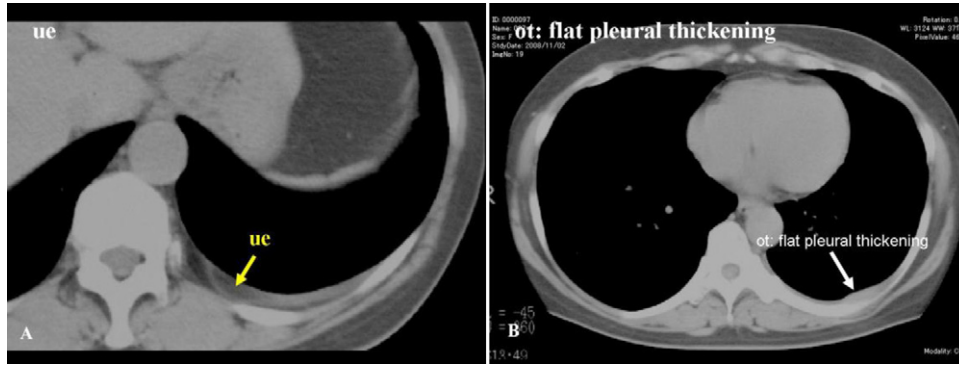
A 52-year-old women with diffuse epithelioid MPM. CT scans show slight unilateral pleural effusion (A) and flat pleural thickening in the left hemithorax (B). According to the CT appearance, the MPM probability was agreed as low probability Grade 2 at mild severity by experts.
